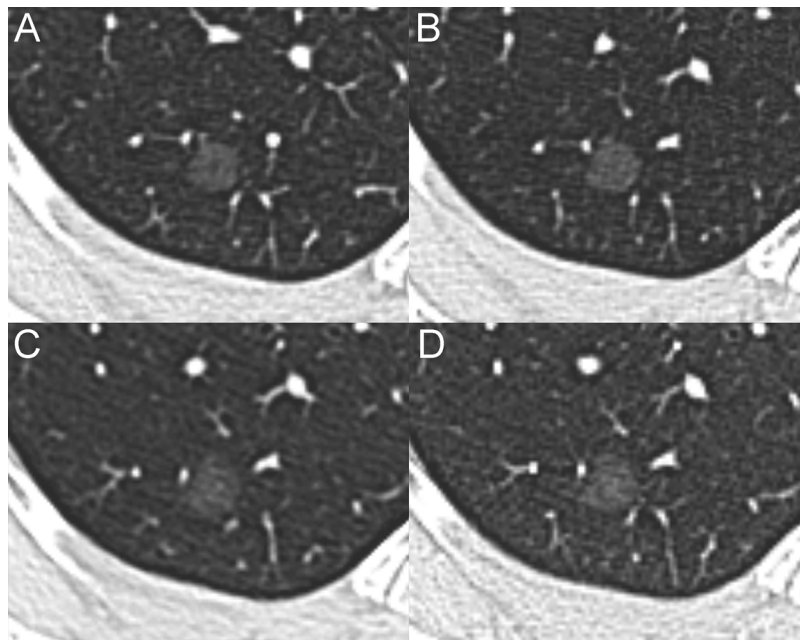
Serial MDCT scans of the stable pGGN. (A) The baseline MDCT shows a pGGN (mean diameter, 10 mm) in the posterior segment of the right upper lobe. The follow-up CT scans performed at 23 (B), 61 (C) and 83 months (D) reveal the stability of the lesion.
